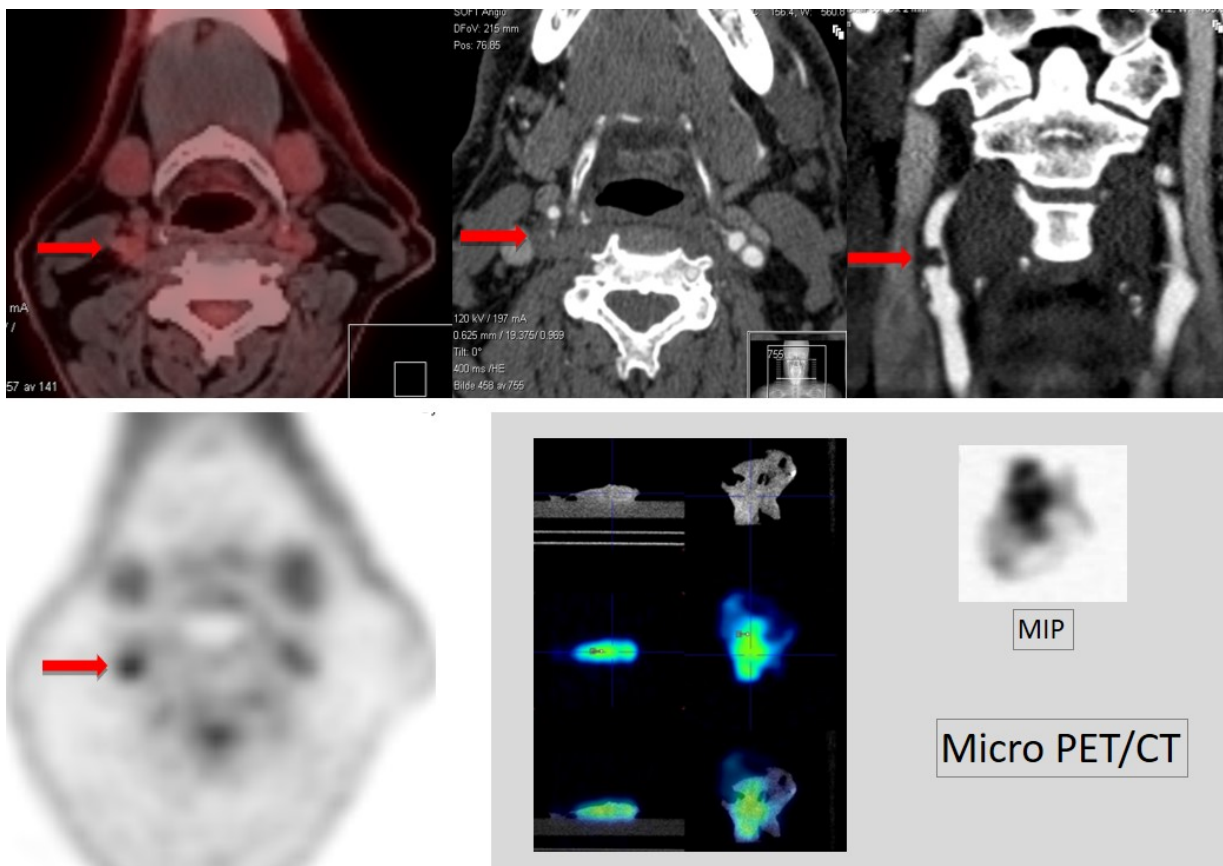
Patient with high uptake on clinical PET (upper panel and bottom panel left) (max SUV_{max} 2.24, mean SUV_{max} 1.97) and with microPET max SUV_{max} 35.9 (bottom panel right). The CTA shows a small homogeneous low-attenuating plaque (no calcification) with severe stenosis (upper panel middle and right). The patient had experienced symptoms two months earlier and the plaque was echolucent on ultrasound.
